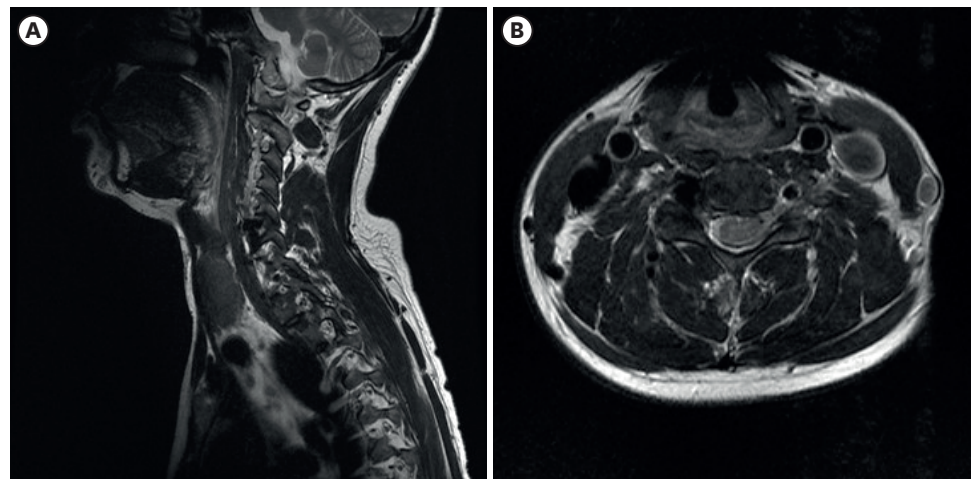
T2-weighted cervical spine magnetic resonance shows abnormal flow void on right C5–6. (A) Abnormally dilated vessel on right C5–6 foraminal zone and extraforaminal zone is seen in sagittal T2-weighted image (arrow). (B) In axial T2-weighted image, it is observed that the abnormal vessel structure occupies the way out of the C6 nerve root (arrow).
